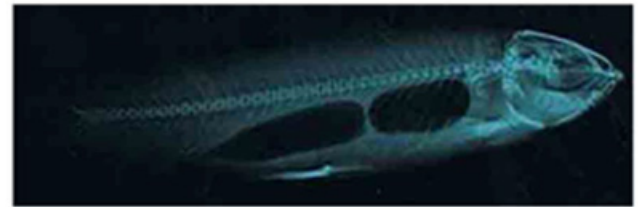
Xray photograph of normal *Cirrhinus mrigala*.
